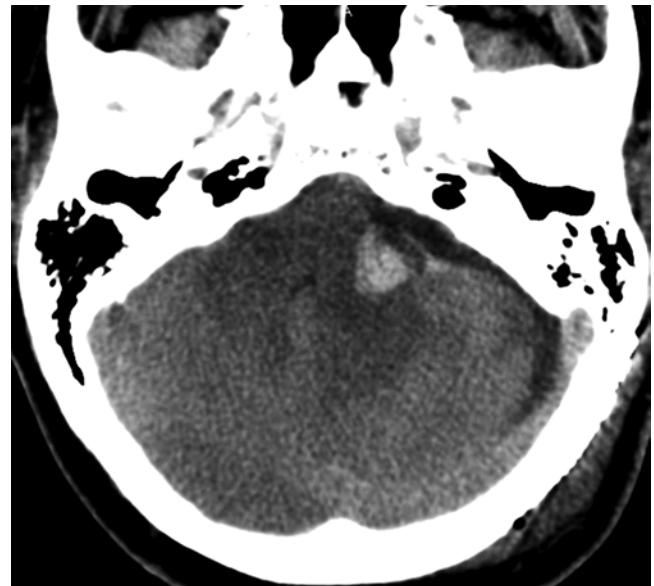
Hemorrhage. Axial CT image showing a hematoma within the resection bed and adjacent brain parenchyma with surrounding edema and mass effect upon the brainstem and fourth ventricle.
